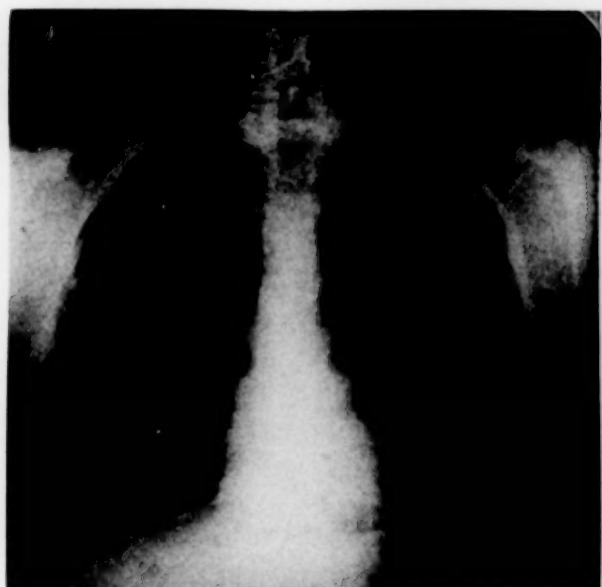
Case 4-229. X-ray taken February 2nd shows that the bronchovascular markings were still slightly greater than normal but the nodular opacities had resolved. The right costophrenic angle was obliterated by a shadow suggestive of atelectasis.
